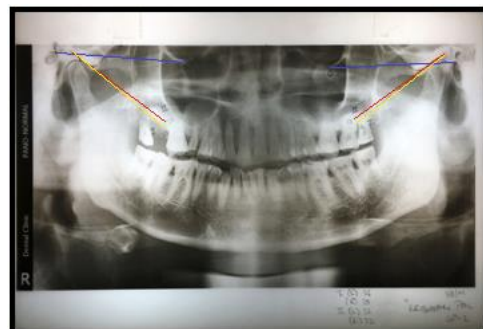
Radiographic analysis for patients over 50 years with maintained occlusion
